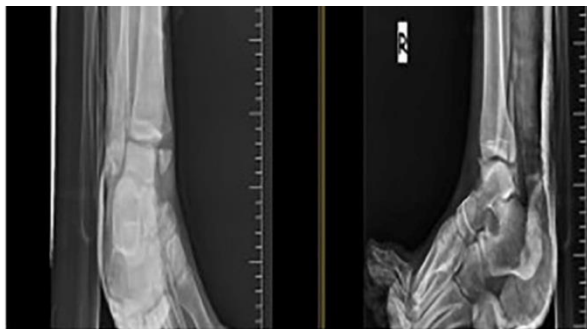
Preop Ap-Lateral ankle radiography
